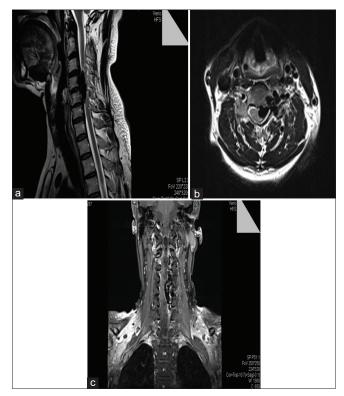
(a) Sagittal view of cervical spine magnetic resonance imaging showing large dilated epidural flow void. (b) Axial view of the cervical spine showing dilated epidural flow voids. (c) Coronal view of cervical spine showing dilated epidural flow voids
